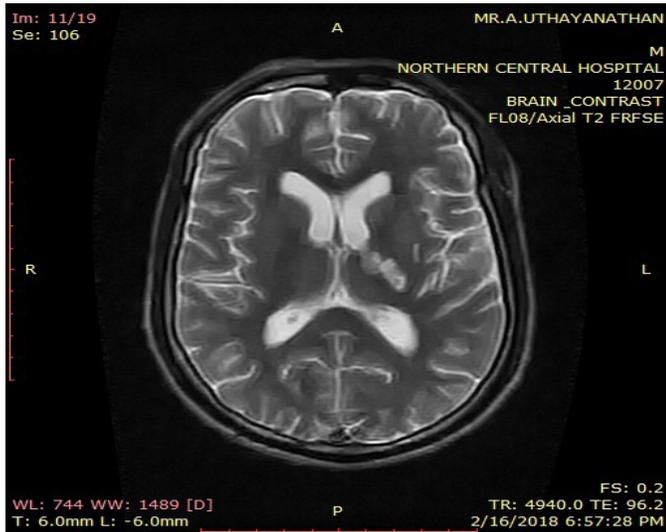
The magnetic resonance imaging showed the basal meningeal enhancement and vasculitic infarction of thalamus, basal ganglia in favoured the diagnosis of tuberculosis meningitis.
